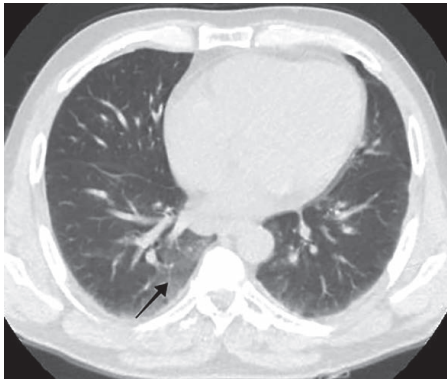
Patient 3: Chest computed tomography on admission (day 7 since symptom onset), when he needed oxygen through low-flow nasal cannula. Ct (cycle threshold) was 10. Subpleural ground-glass opacities with basal predominance (black arrow).
